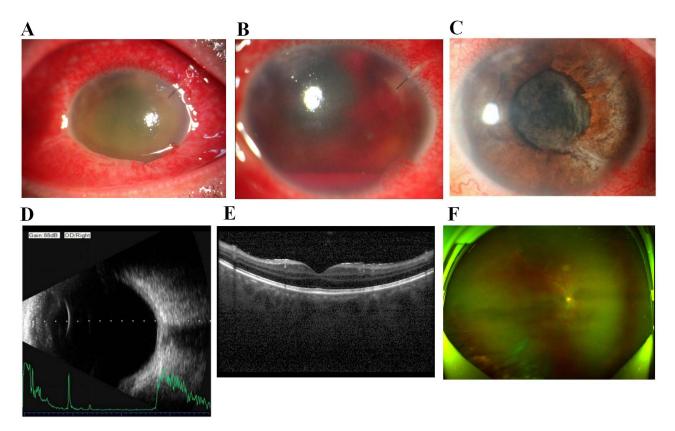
Figure I Images of the anterior segment of the right eye at initial diagnosis (A), the I<sup>st</sup> day post-surgery (B), and 2 months post-treatment (C). The results of the B-ultrasound examination (D), optical coherence tomography (E), and fundoscopy (F) of the right eye, showing no significant abnormality.
